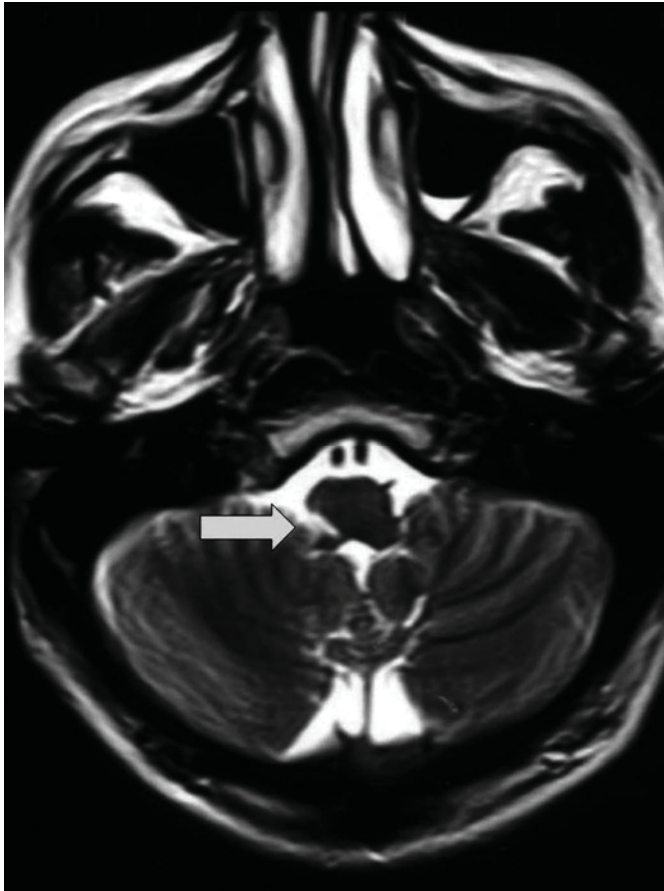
FLAIR MRI sequence showing a hyperintense lesion (arrow) in the right lateral medullary region.
